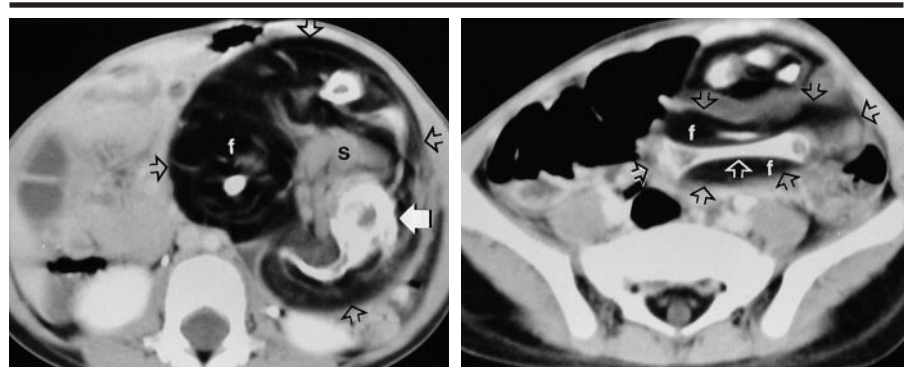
Case 2. Fetus in fetu. (a) Transverse CT scan of the upper abdomen reveals a heterogeneous mass (open arrows) that has fat (*f*), soft tissue (*s*), and bony components. The bony components (solid arrow) resemble a vertebral body in cross-section. (b) Transverse CT scan at the level of the pelvis demonstrates a soft-tissue mass (black arrows) that consists of an ossific component that resembles a femur (white arrow) surrounded by fat (*f*).
